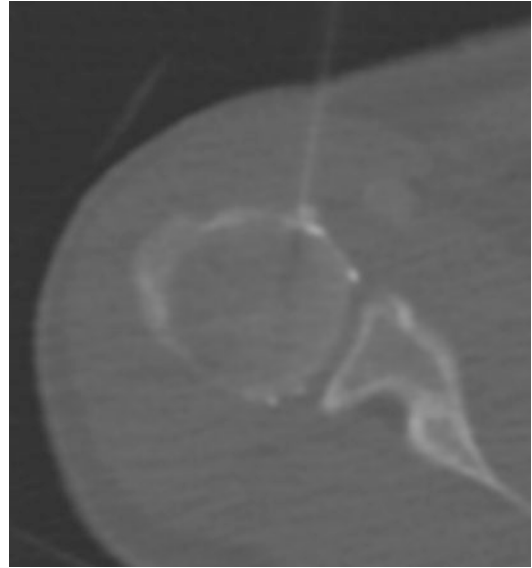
CT-guided puncture of the right shoulder joint for application of MRI contrast agent
